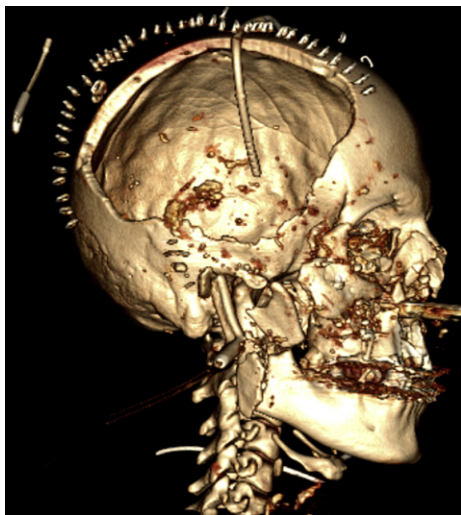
Three-dimensional CT of patient in Fig. 3. Note extensive comminution typical with explosive injury to the face.
